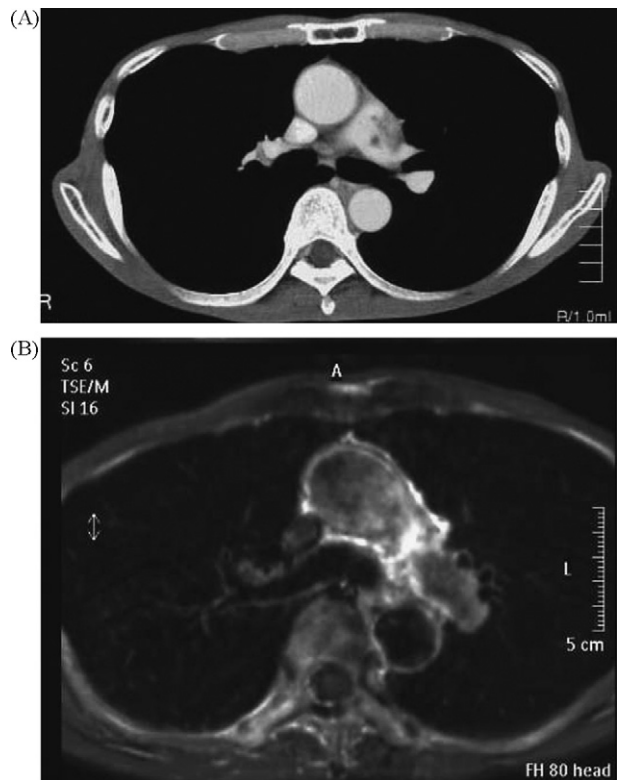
Computed tomography (CT, A) and magnetic resonance imaging (MRI, B) showed a tumorous lesion in the left pulmonary artery and artery wall thickening and stenotic lesion in the main trunk and the left pulmonary artery.
